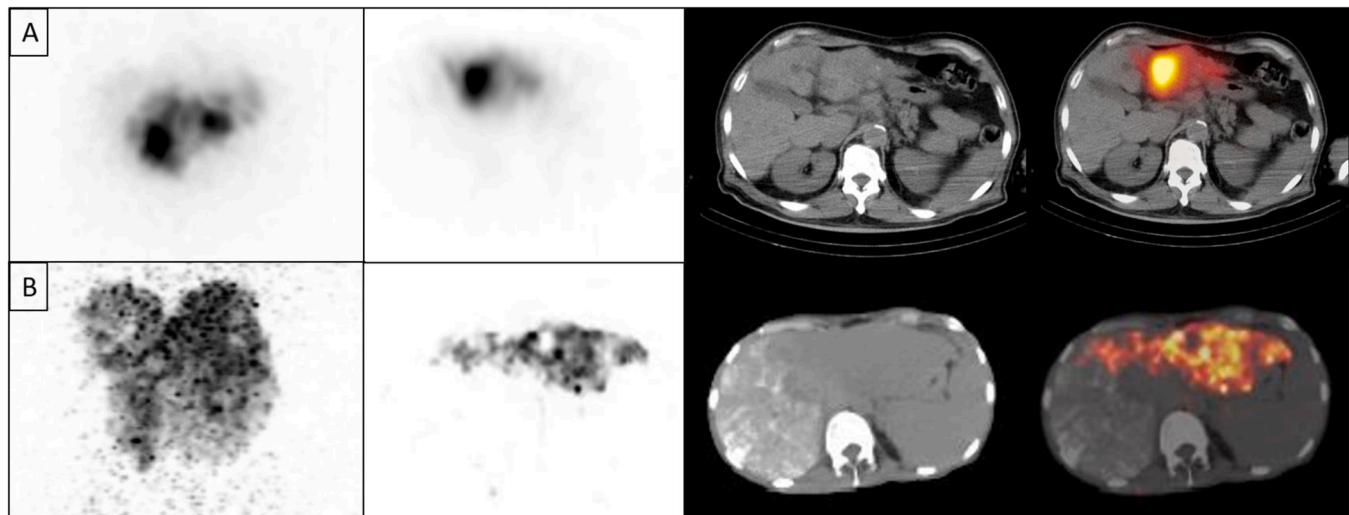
(A) Y-90-resin microspheres Maximum Intensity Projection (MIP), axial SPECT, CT and fused SPECT/CT images showing heterogenous tracer uptake in the HCC involving the left lobe of the liver. (B) Y-90-glass microspheres Maximum Intensity Projection (MIP), axial PET, CT and fused PET/CT images showing tracer uptake in the left lobe of the liver. In the right lobe, bland embolization with lipiodol was performed.
